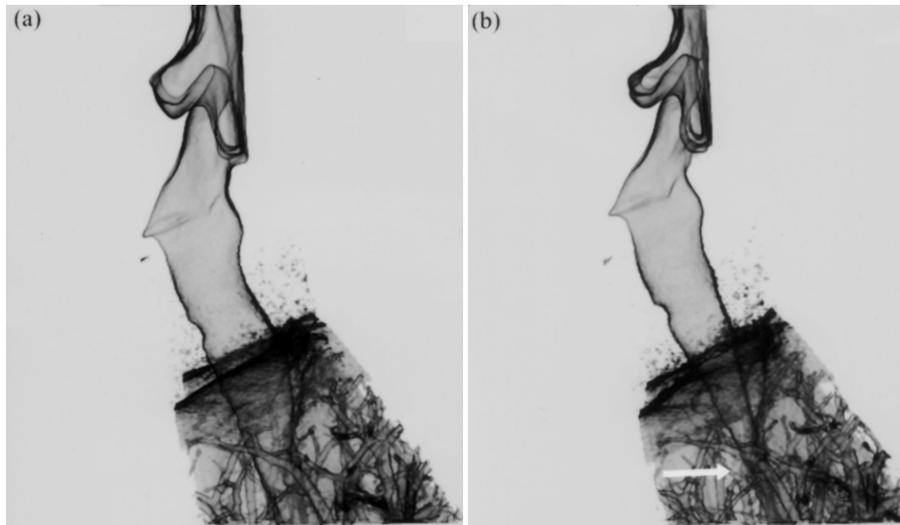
4D dynamic volume CT of inspiration (a) and expiration (b) showed extreme luminal narrowing at the distal trachea during expiration (b. white arrow).
